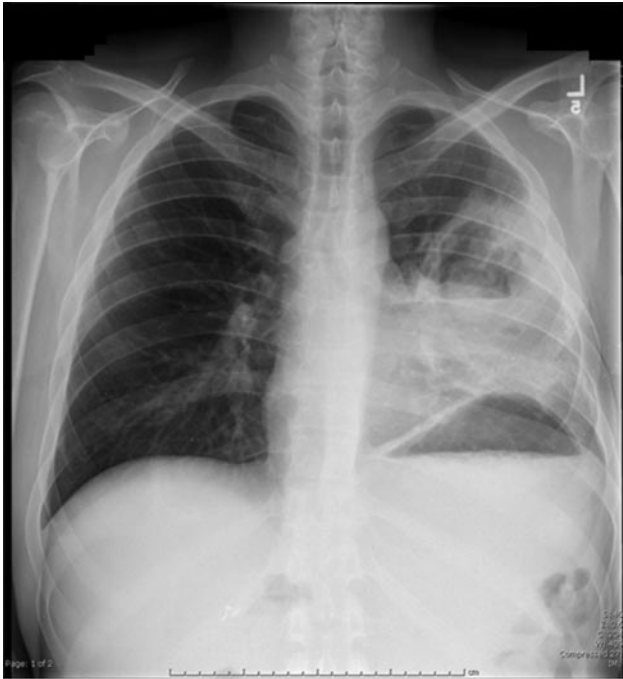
Chest x-ray shows opacification of the left upper lobe, multiple air/fluid levels, and a 4 cm round mass-like lesion projecting over one of the air/fluid levels.
